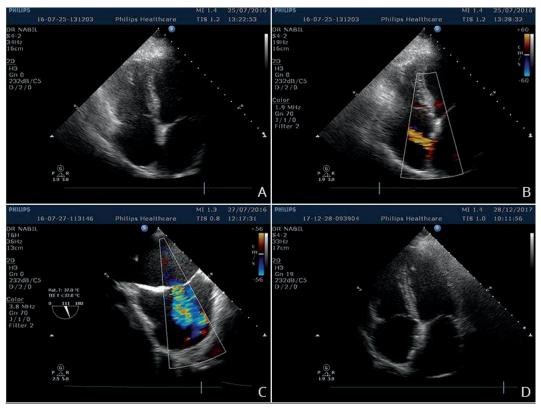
A secundum atrial septal defect (ASD) with left-to-right shunt was confirmed by 2-dimensional transthoracic echocardiogram (TTE) (Panel A), 2-dimensional TTE colour Doppler (Panel B). Transesophageal bicaval view with colour Doppler (TEE) (Panel C) and TTE echocardiography of the final result after transcatheter closure with Amplatzer occluder (Panel D).
